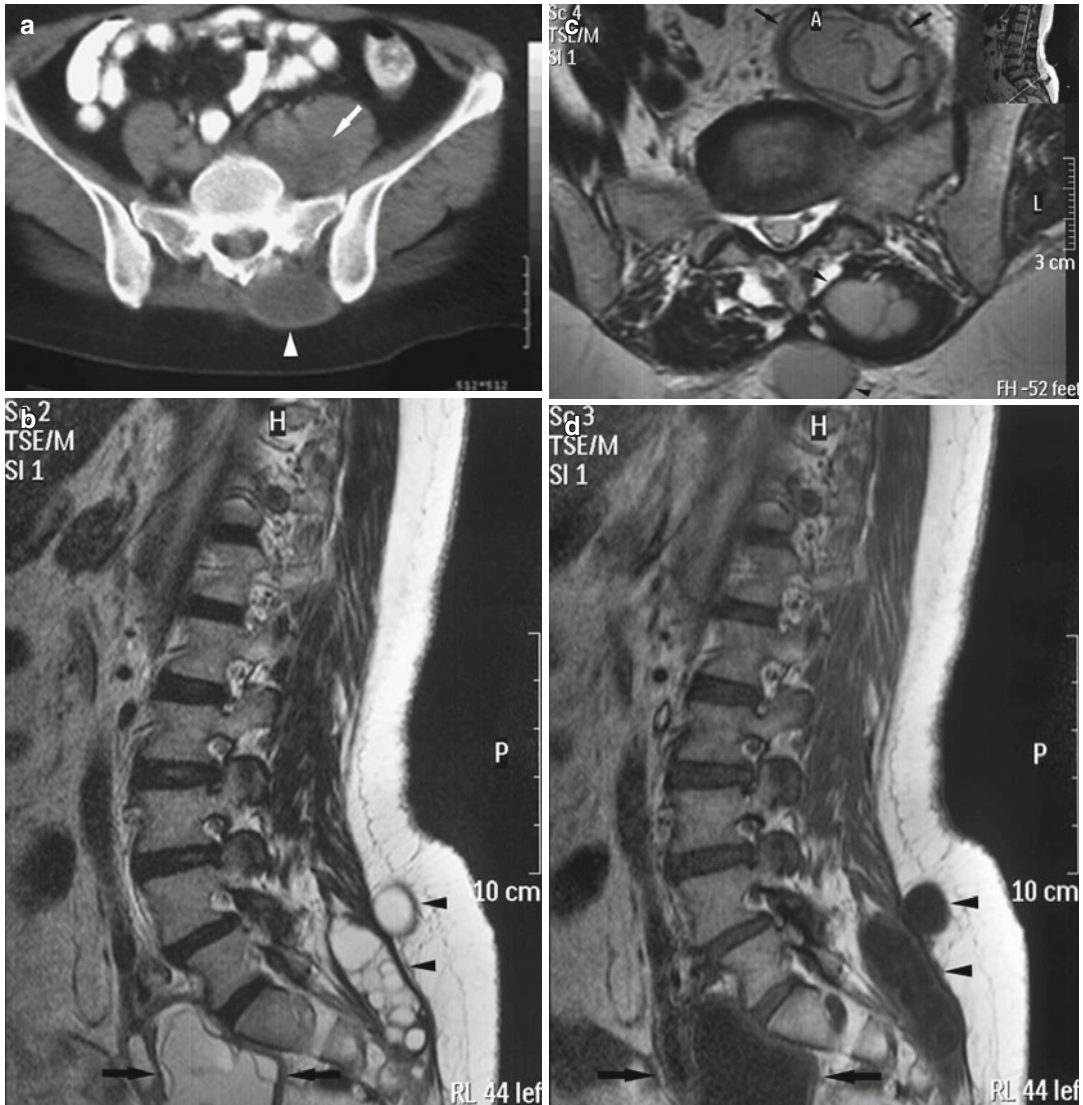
In a 46-year-old female with multiple sacral paraspinous hydatid cysts on the left side, unenhanced axial pelvic CT image (a) demonstrates a hypodense hydatid cyst (white arrow) in the left psoas muscle which shows a close relation with left sacral neural foramina and nerves. Posterior to the sacrum, another hydatid lesion (white arrowhead) is located in the erector spinae muscle. MRI reveals multicystic-multiloculated sacral paraspinous hydatid lesions (black arrows: lesion anterior to the sacrum, black arrowheads: lesions posterior to the sacrum) as
